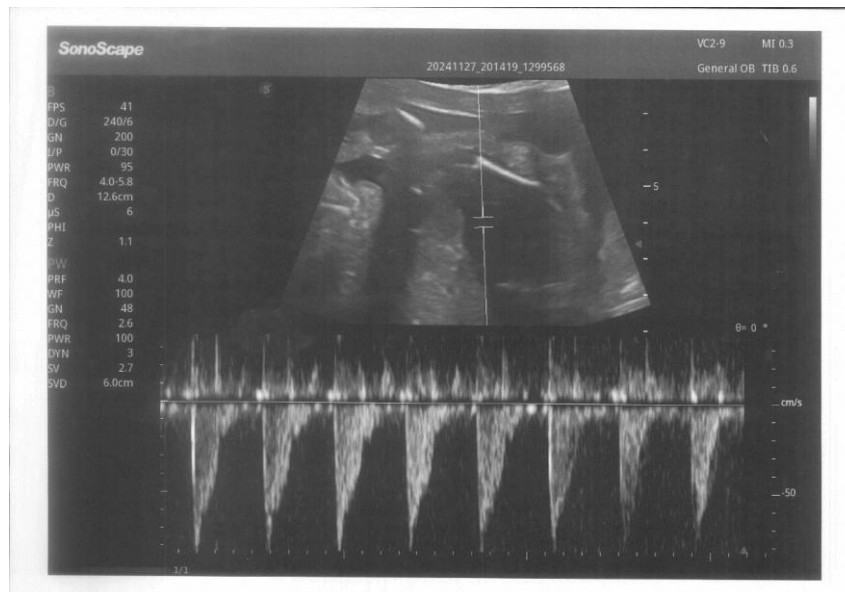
A 25 years old PG admitted for routine antenatal ultrasound examination , GA 38weeks+2 days, SLF , HR(130 bpm) with adequate movement, AFI(9cm), placental grading grade 3, colon grading grade 2, Doppler examination: MPA RI (0.73), PI (1.6), AT(53ms), ET(173ms), AT/ET(0.30),the neonatal outcome delivery within 24 hours after u/s examination, NICU admission for RDS (NO) .
